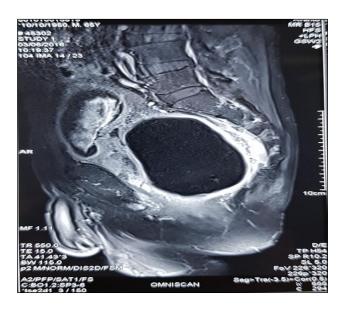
A sagittal view of MRI T1FS pelvis showed a well defined lesion within the rectal lumen which is hypointense in all sequences.
